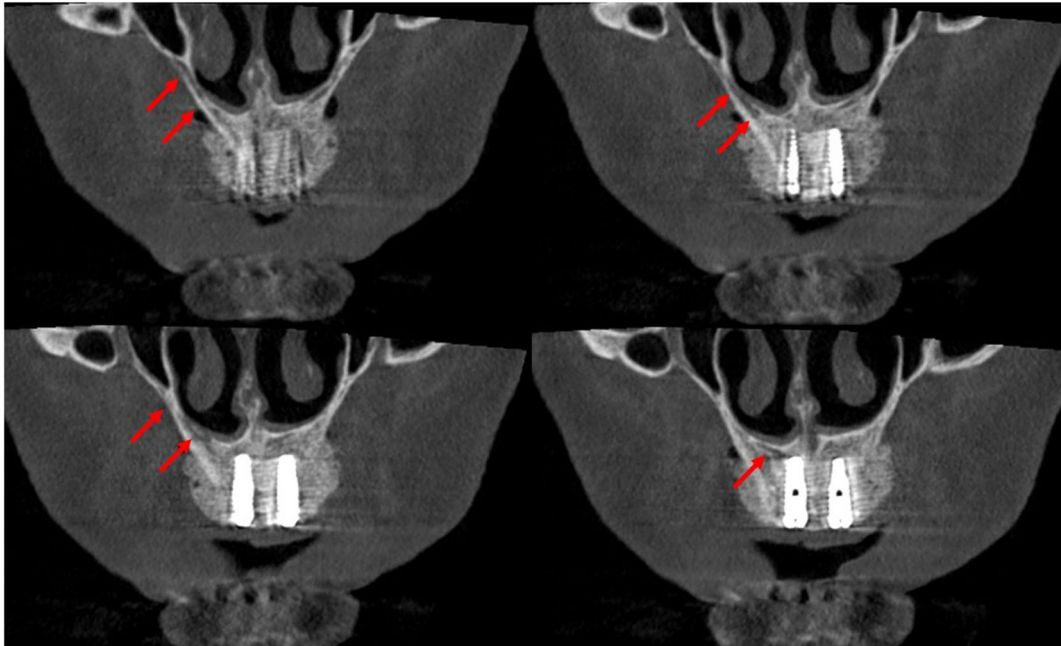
Course of Canalis Sinuosus (CS) highlighted in the coronal reconstruction of the post-op CBCT image
